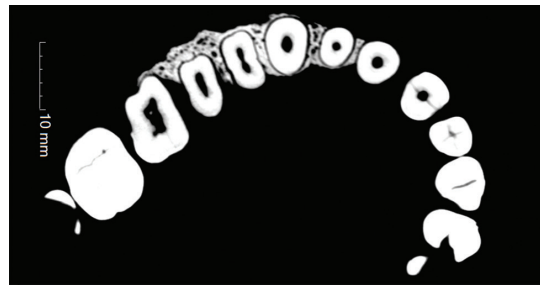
CT image showing the different shapes of teeth 11-16 at the crest of the alveolar bone.
